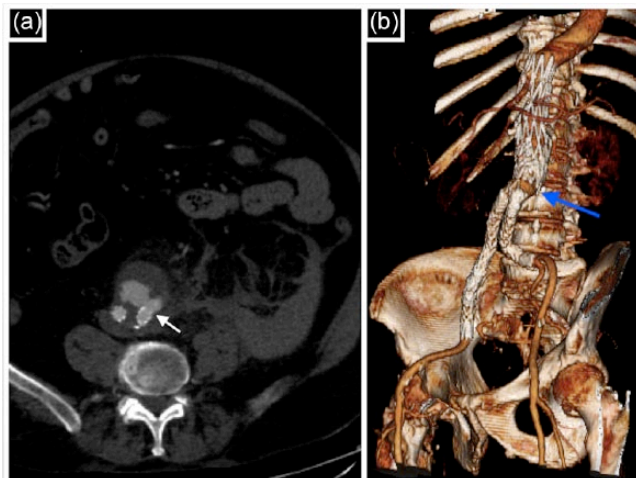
(a) Pre-operative CTA displaying AAA rupture with blood in the retroperitoneum and a type 3 endoleak (white arrow) from the left graft limb. (b) Post-operative CT 3D reconstruction showing final bilateral limb placements, leaving an 18-mm gap (blue arrow) only lined with initial Vanguard graft.
